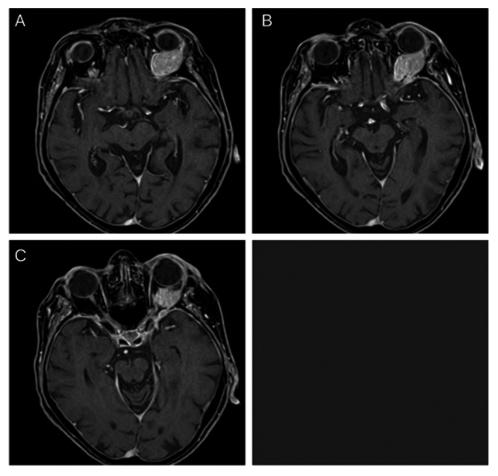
Axial views of T2-weighted magnetic resonance imaging scan demonstrating the left orbital squamous cell carcinoma (A and B) with extension into the left cavernous sinus (C).
